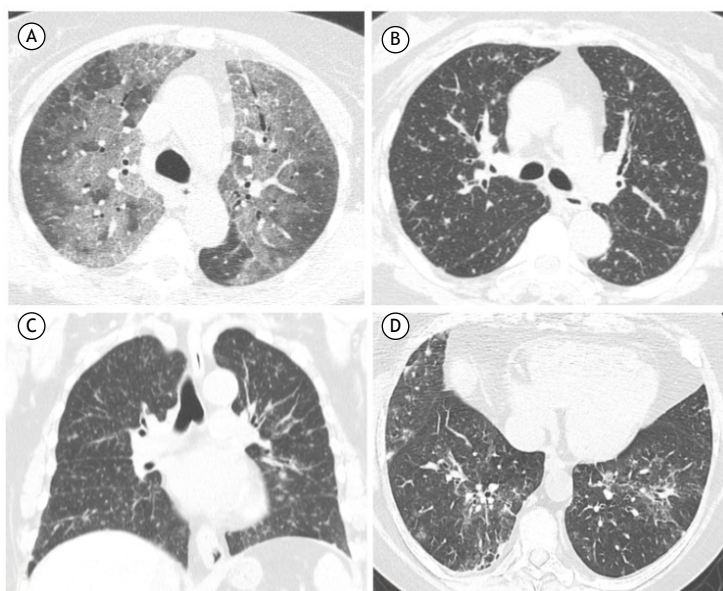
In A, axial CT scan showing pulmonary ground-glass opacities, predominantly in the upper lobes, in a 62-year-old female patient with RA after receiving the second dose of adalimumab. In B and C, CT scans showing diffuse, predominantly perilymphatic, micronodules in a patient with RA and sarcoid-like reaction associated with the use of etanercept. In D, axial reconstruction of a CT scan showing ground-glass opacities and organizing pneumonia patterns in the lower lobes of a patient with systemic lupus erythematosus after rituximab use.
